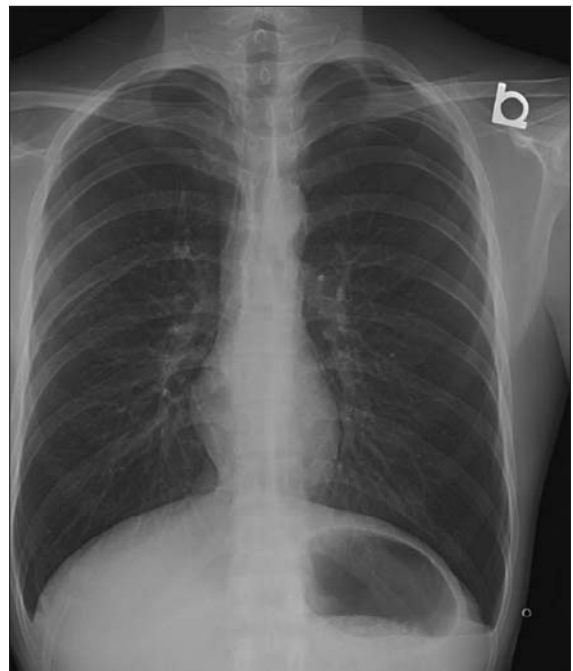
X-ray performed 24 hours later.
